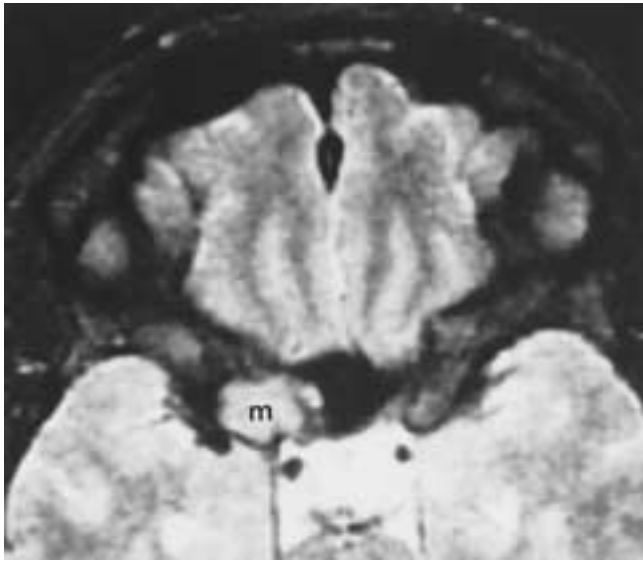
Multiple myeloma. Axial T2-weighted MR scan shows a mass (*m*) involving the right lesser wing and optic canal.
